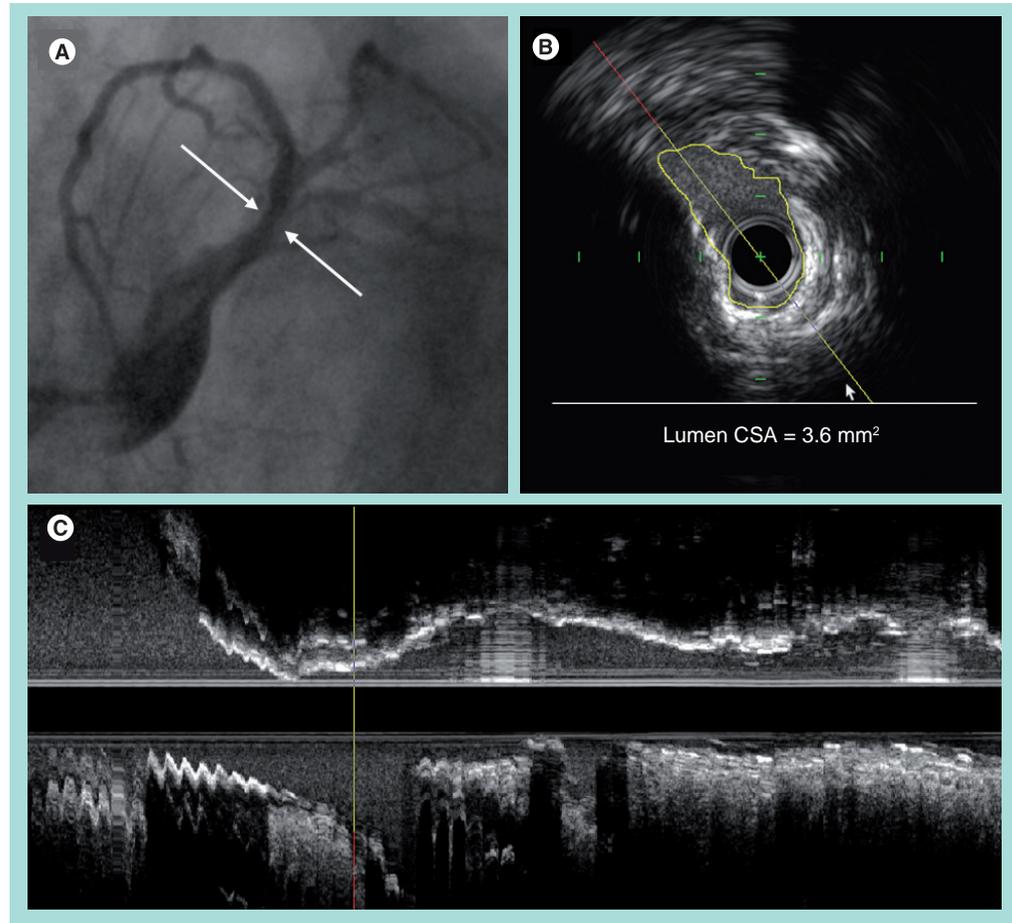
The value of intravascular ultrasound in left main trunk coronary disease.
